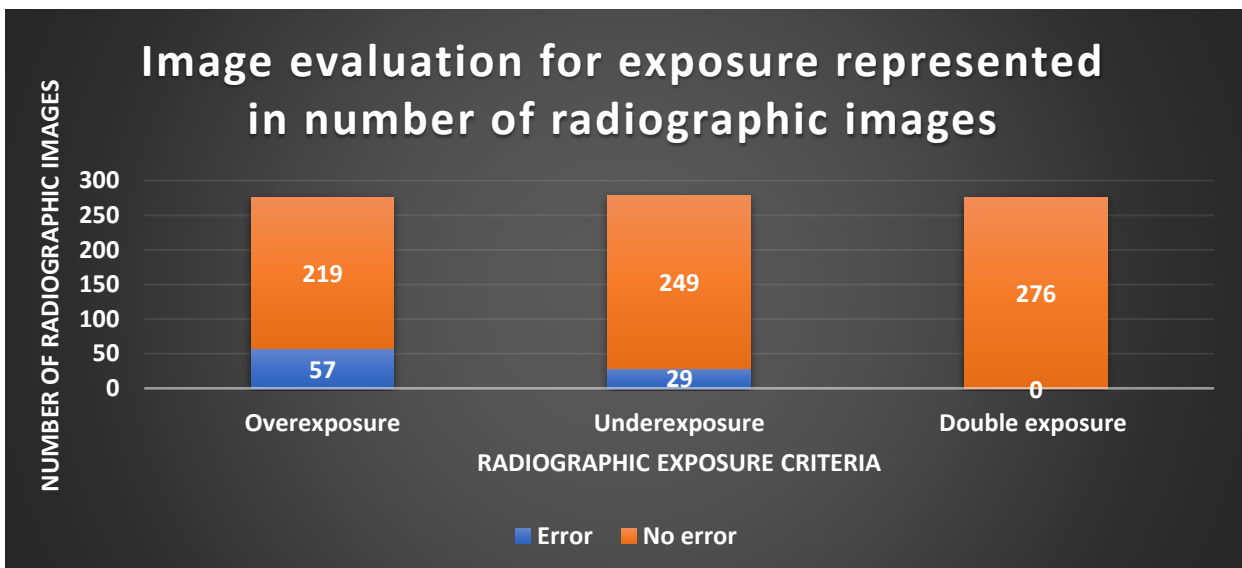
Radiographic image evaluation for exposure (created by the researcher)
